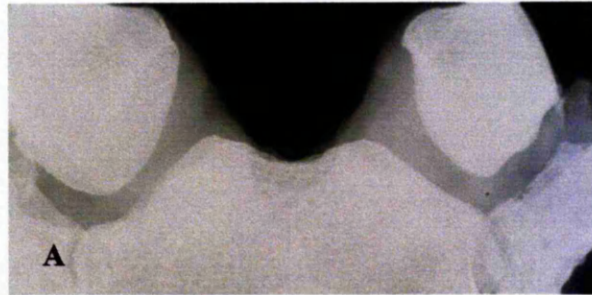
X-rays of the sternoclavicular joints.
